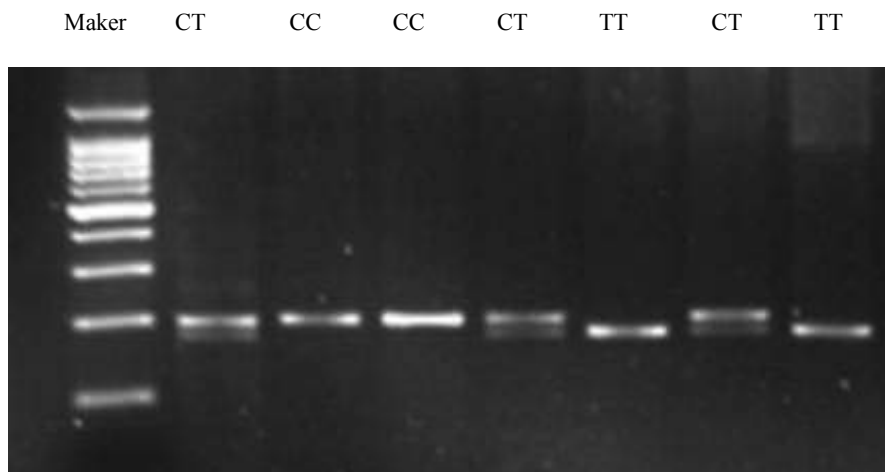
Sequence change and restriction enzyme analysis for the alanine to valine substitution. Wild type CC^{-/-}, homozygous mutant TT^{+/+}, heterozygous type CT^{+/-}.
